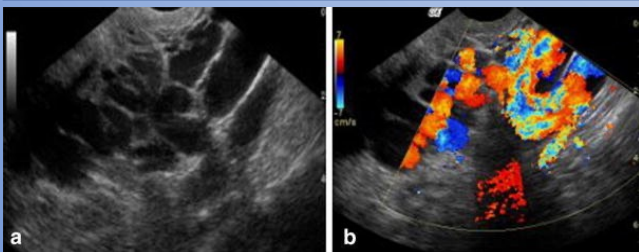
Transvaginal ultrasound with use of B-mode (a) and color-doppler (b) to show engorgement of left ovarian vein.
